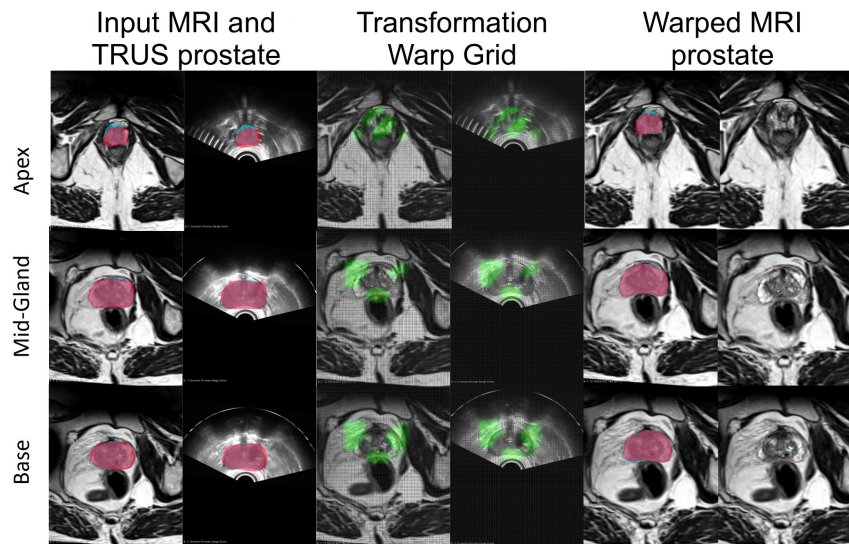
Sample MRI-TRUS registration result from a 65yr-old male, using 3D segmented surfaces used as inputs to the model, and a B-spline grid (interpolated from the NICP deformation field) to warp the MRI onto the targeted TRUS. The green areas represent the registered prostate surface on the TRUS image and the red areas represent the prostate gland on the MRI.
